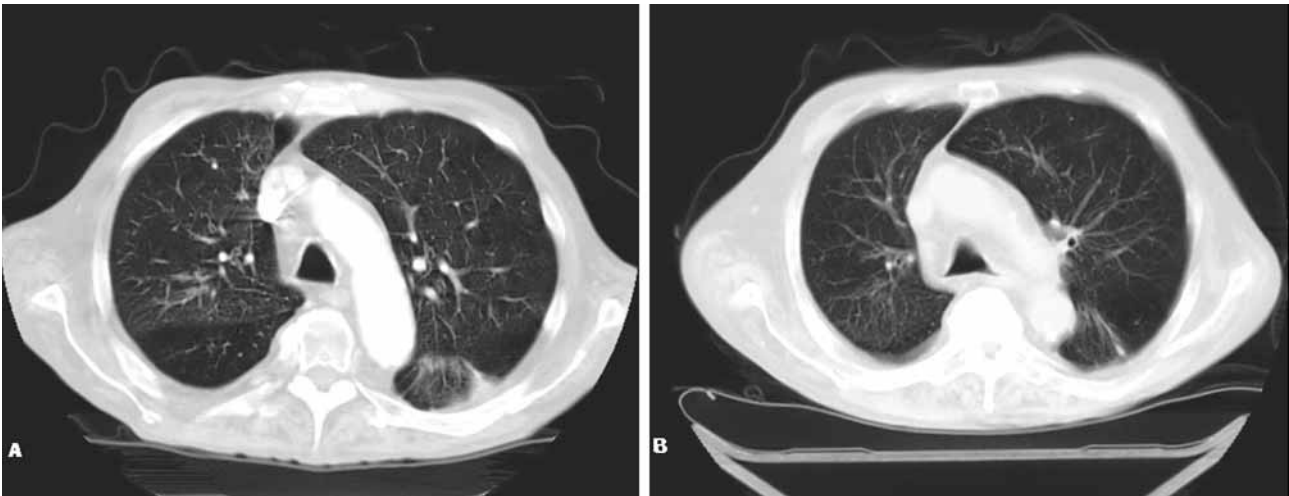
Sagittal CT-images of the lung before (A) and after six months of treatment (B) for nocardiosis due to *Nocardia farcinica*
